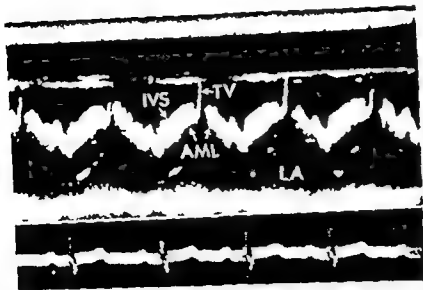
A typical echocardiogram in the beam direction in which the anterior mitral leaflet the interventricular septum, and the tricuspid valve interact. In systole the anterior mitral leaflet is just posterior and parallel to the interventricular septum. The anterior mitral leaflet becomes the tricuspid valve as soon as the opening motion of the mitral valve has begun. The interruption of the septum after the opening motion of the mitral valve is sometimes recorded in ECD. In diastole the mitral valve is completely superimposed on the septum.
